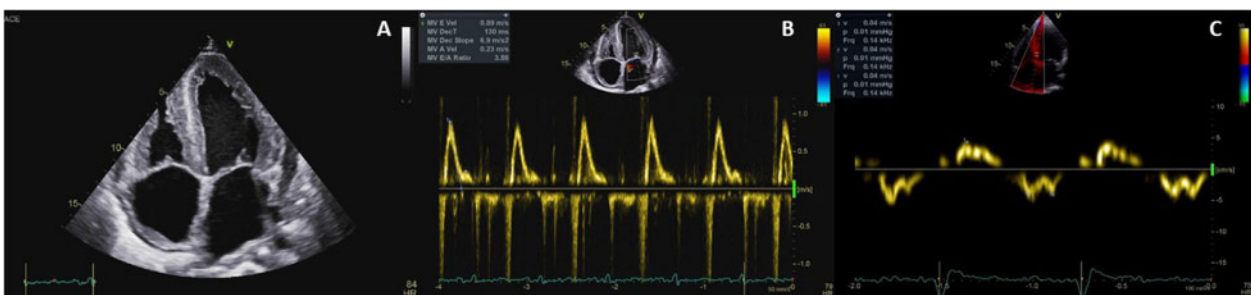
(A) Four-chamber view of a young woman recently diagnosed with ATTR amyloidosis, showing biatrial enlargement, thickened right atrial wall and inter-atrial septum, LV hypertrophy, and mild pericardial effusion. (B) Restrictive mitral flow pattern (E/A ratio of 3.86). (C) Tissue Doppler imaging of the mitral annulus with very low systolic and diastolic septal velocities and a E/e' ratio of 22.
